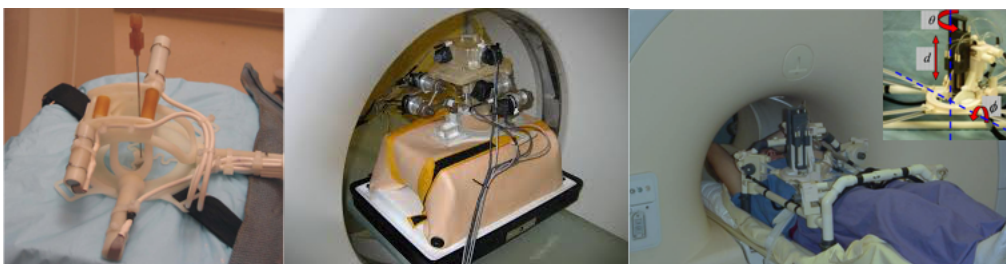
Patient-mounted research prototypes. From left to right: Robopsy, CT-Bot, LPR and close view of needle holder.
